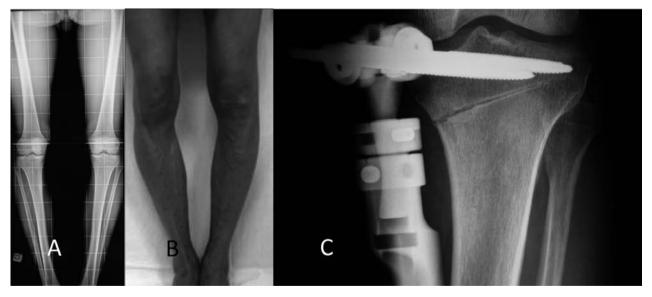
Bilateral genu varum in a patient of 37 years of age; preoperative long weight bearing lower limbs radiographs (A), clinical image (B) and postoperative x-ray.
